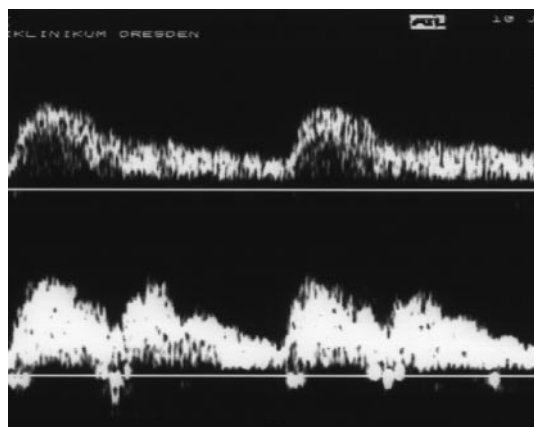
Recording of renal artery blood flow as demonstrated by Doppler ultrasound at rest (above) and during EECP (below) in a healthy volunteer. The lower panel demonstrates an additional peak representing blood flow during diastole when EECP is in operation.
